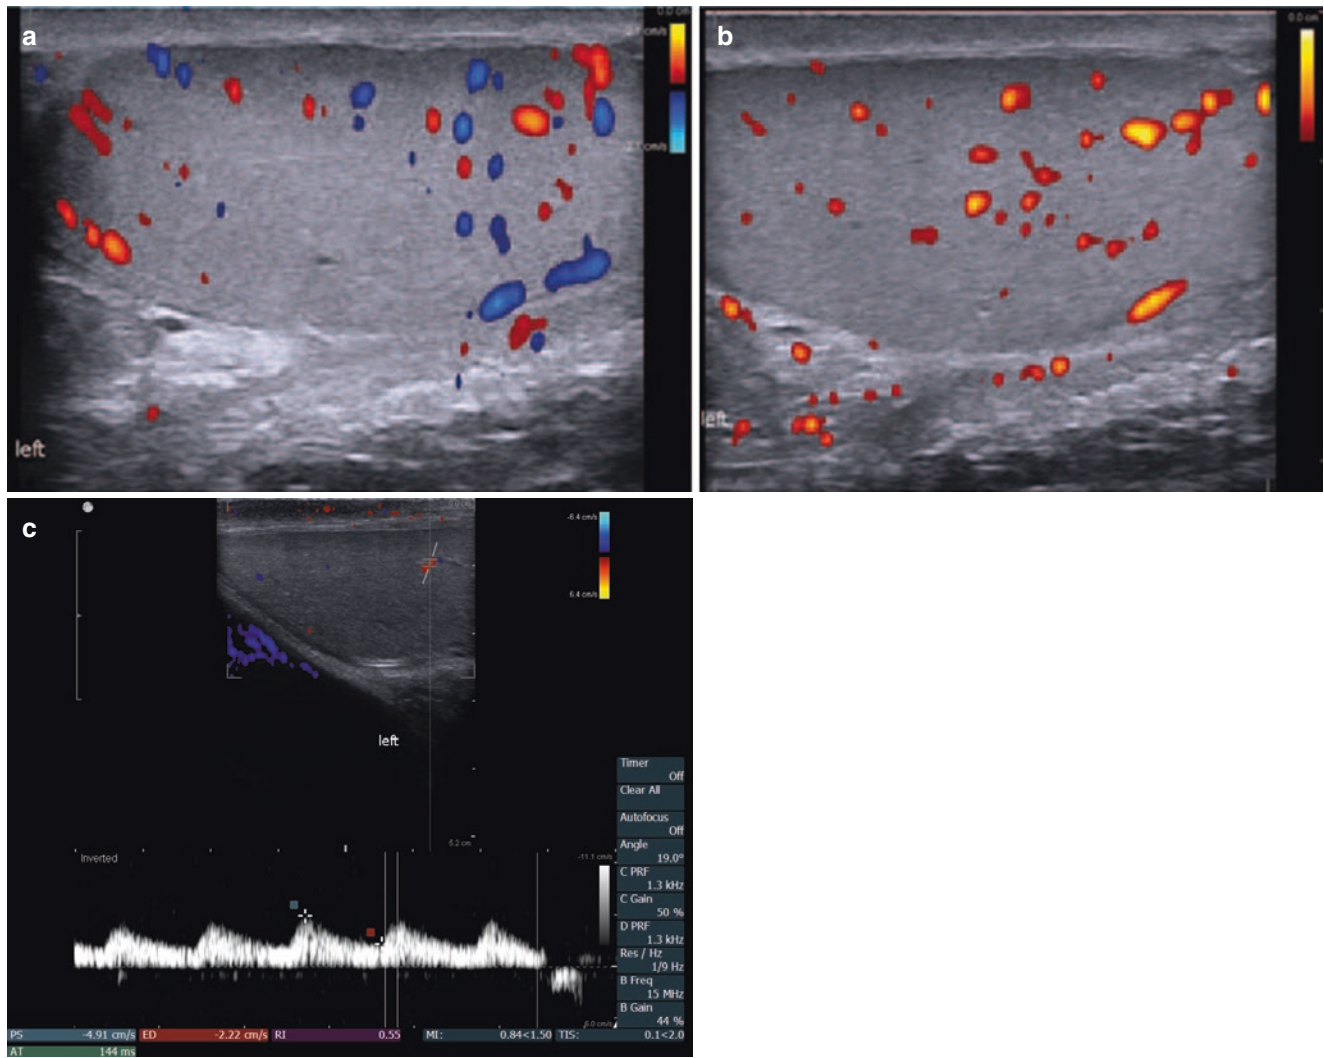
(a) Testicular blood flow is best visualized using color Doppler. Color Doppler is shown in the image on the left as documented by the discontinuous color bar in the image. (Image courtesy of Dr. Bruce Gilbert.) (b) Power Doppler is used in the images on the right, which is more sensitive for flow but does not show
